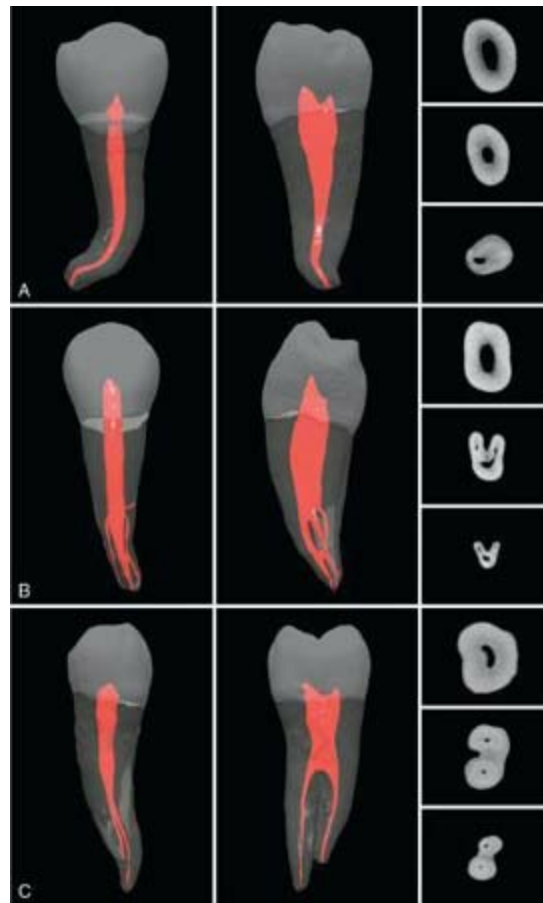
μ CT scans of mandibular second premolars. A, Common anatomic presentation. B, Second premolar with significant canal deviations in the middle to apical third. C, Second premolar with fused root that exhibits two distinct canals. All teeth are shown from both a buccal (vestibular) and a proximal perspective, along with the cross-sectional anatomy at the coronal, middle, and apical levels. (See Video 7.16 online at the Expert Consult site for rotational views of these teeth.)
